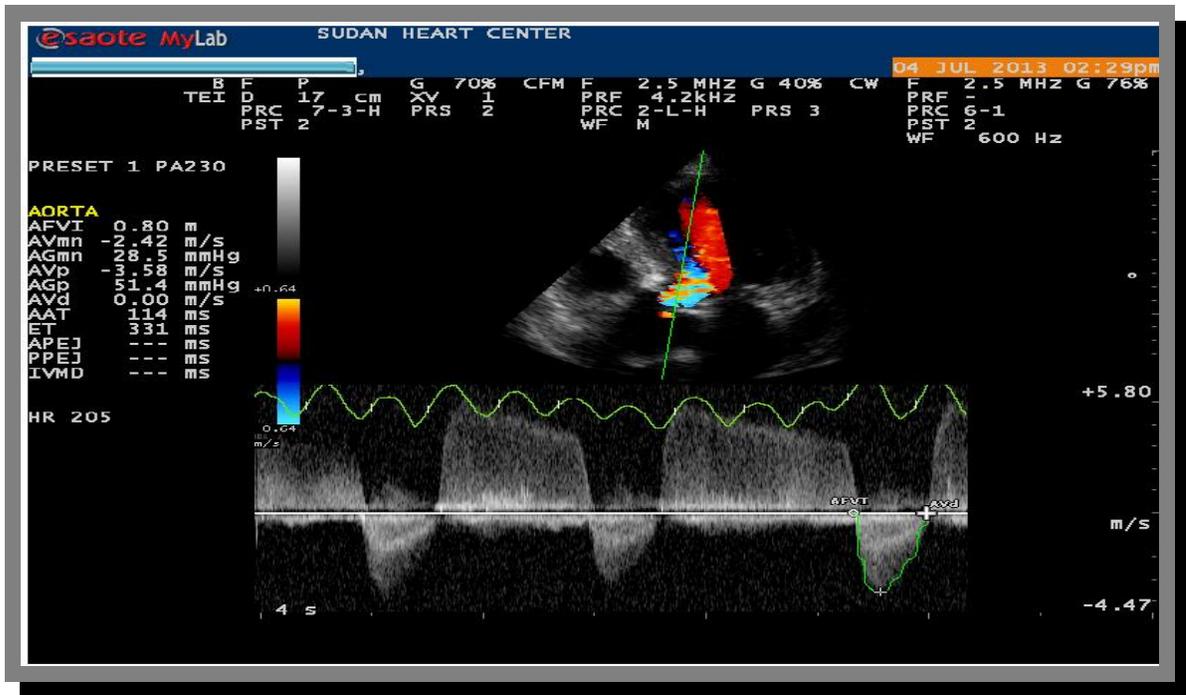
Continuous wave Doppler signal of aorta with a peak velocity of approximately 2.42 m/s.
